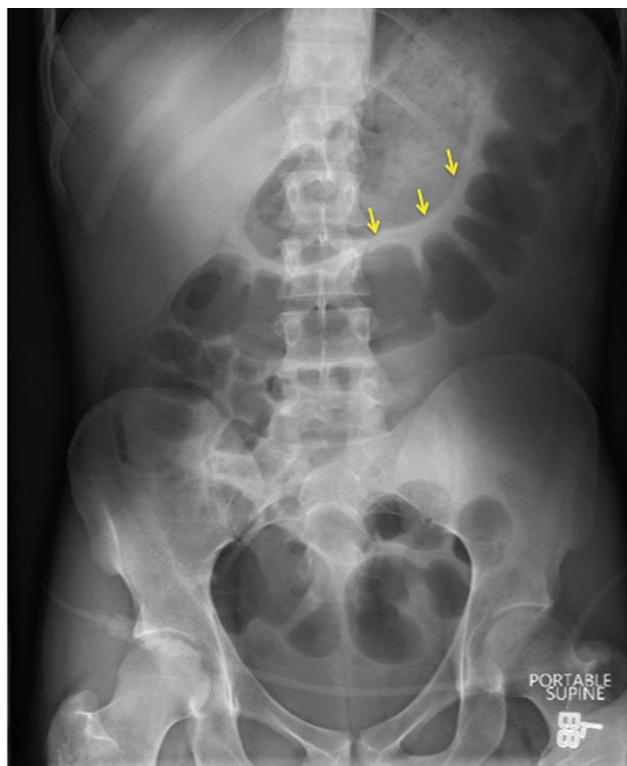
Abdominal radiograph showing the typical thumbprinting sign (arrow), consistent with colonic wall thickening.
